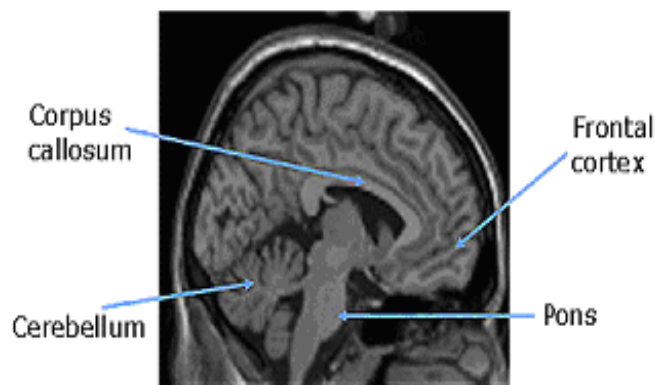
Conventional MRI of the human brain
